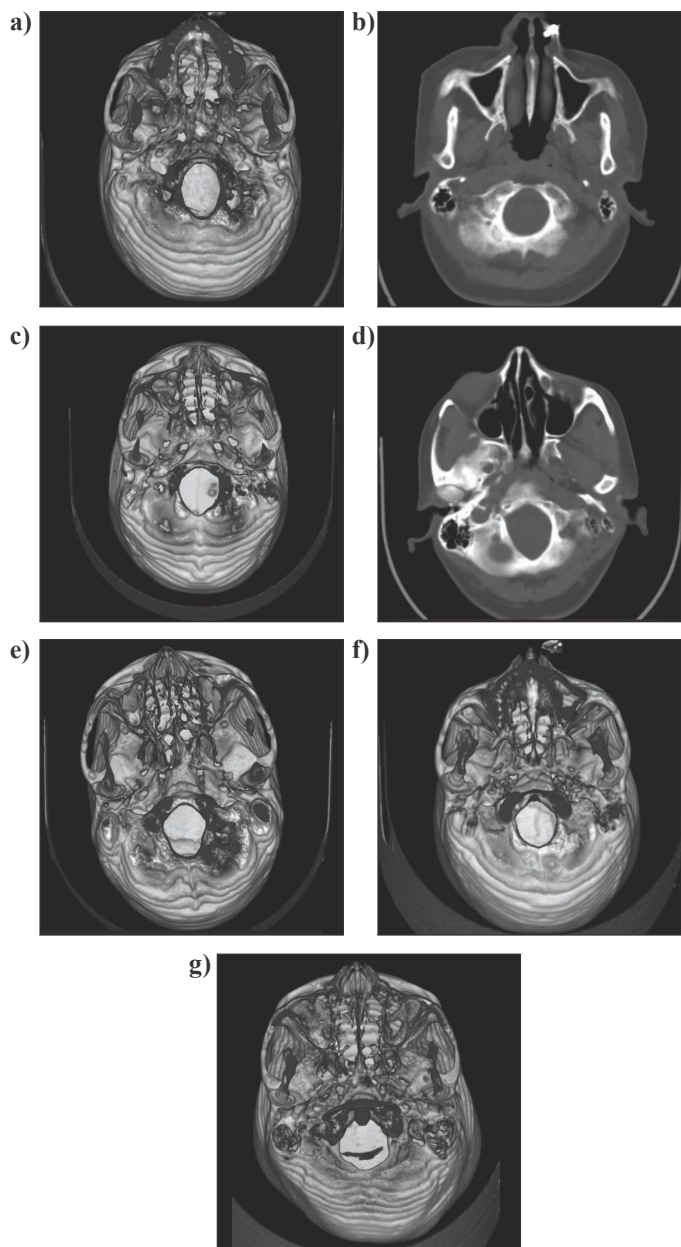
CT Images of different shapes of foramen magnum a) oval, b) round, c) egg, d) tetragonal, e) pentagonal, f) hexagonal, g) irregular.
